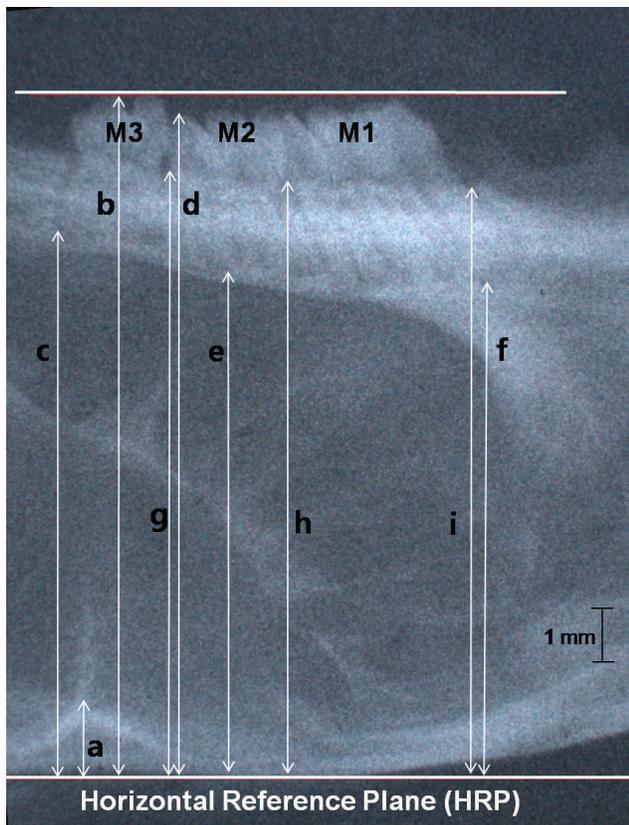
Measurements on a periapical radiograph. (a) Frontal-squamosal intersection at the temporal crest¹⁴; (b) middle cusp tip of maxillary third molar (M3); (c) M3 distal root apex; (d) distal cusp tip of maxillary second molar (M2); (e) M2 distal root apex; (f) maxillary first molar (M1) mesial root apex; (g) alveolar crest between M2 and M3; (h) alveolar crest between M1 and M2; (i) alveolar crest on the M1 mesial side.
